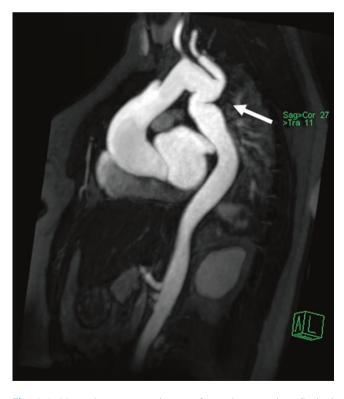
Magnetic resonance image of pseudocoarctation. Sagittal magnetic resonance image angiogram of the thoracic aorta in a 39-year-old man with a history of pseudocoarctation demonstrating significant tortuosity of the proximal descending aorta (arrow)
